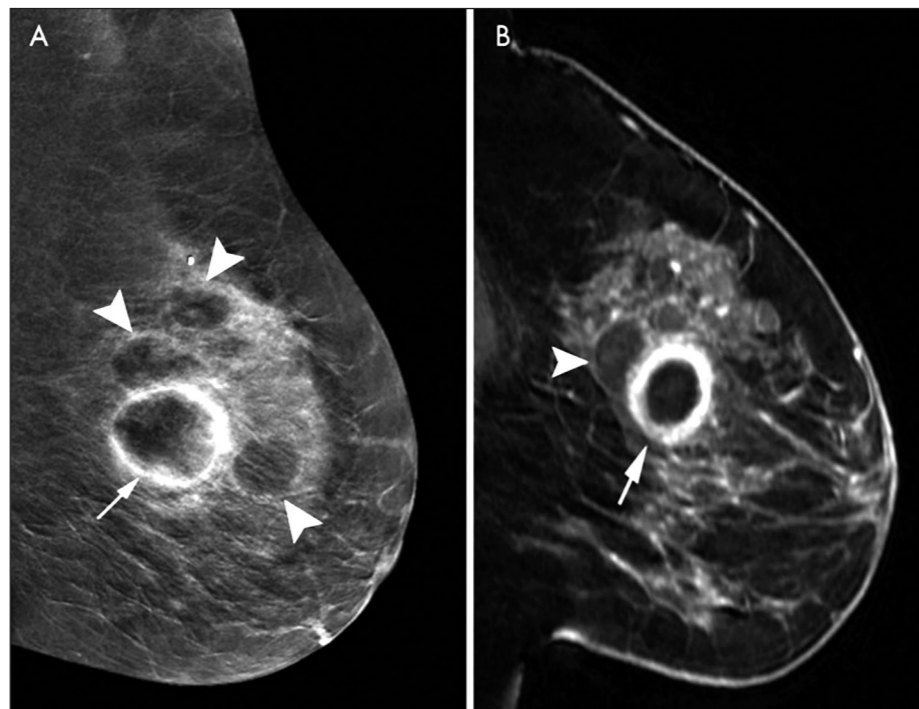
Presentation of the same lesion by CEM and MRI method
